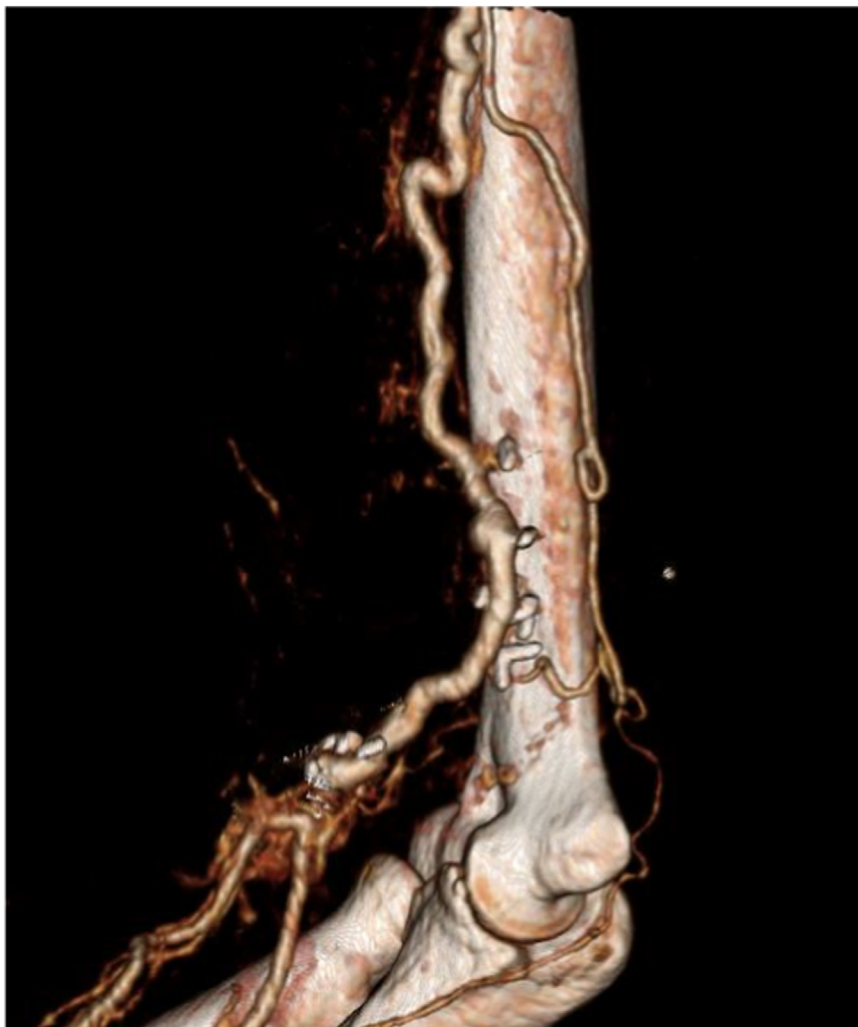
Three weeks after surgery, contrast-enhanced dynamic computed tomography (CT) revealed no aneurysm and patency of the saphenous vein graft.
